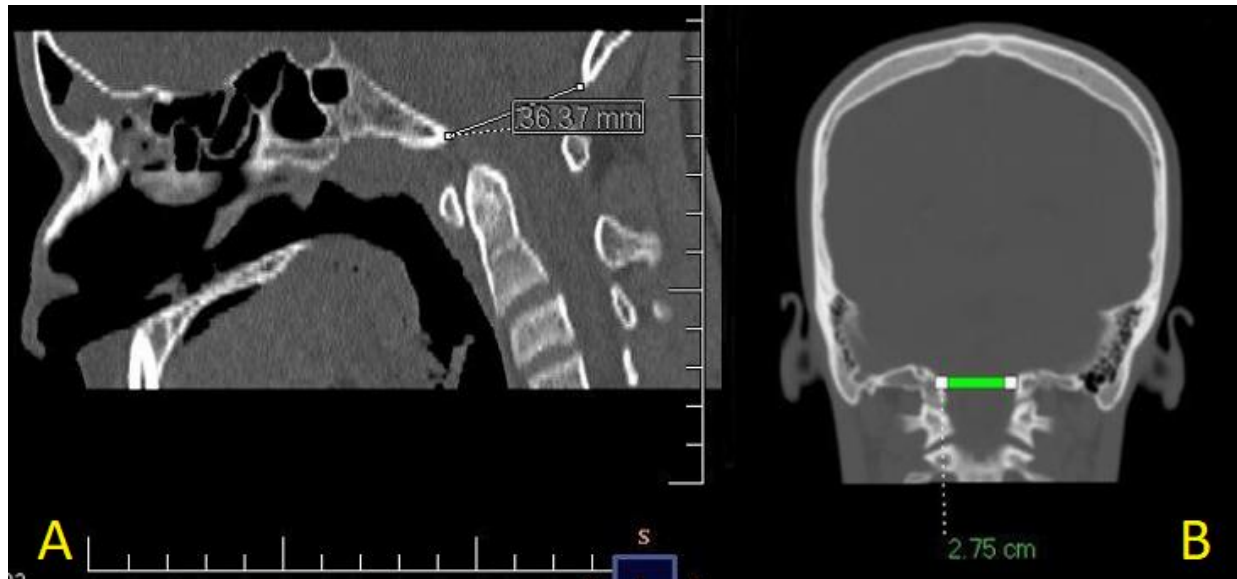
Confirmation of FM diameters using reformatted CT images. A: Anteroposterior diameter measured in the sagittal reformatted image. B: Transverse diameter measured in the coronal reformatted image.
